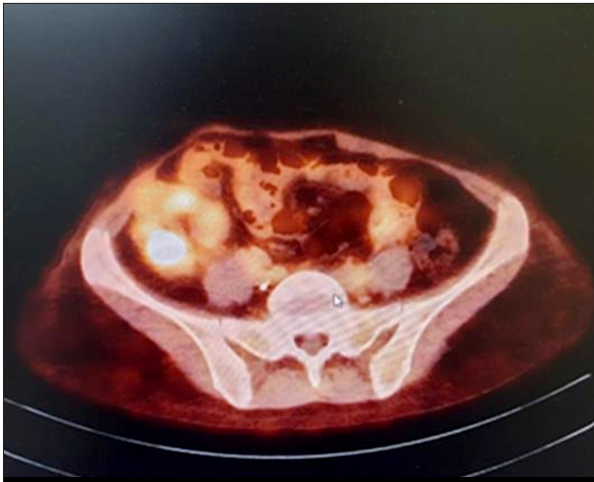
PET-CT. Metabolically active mass in the renal allograft.
